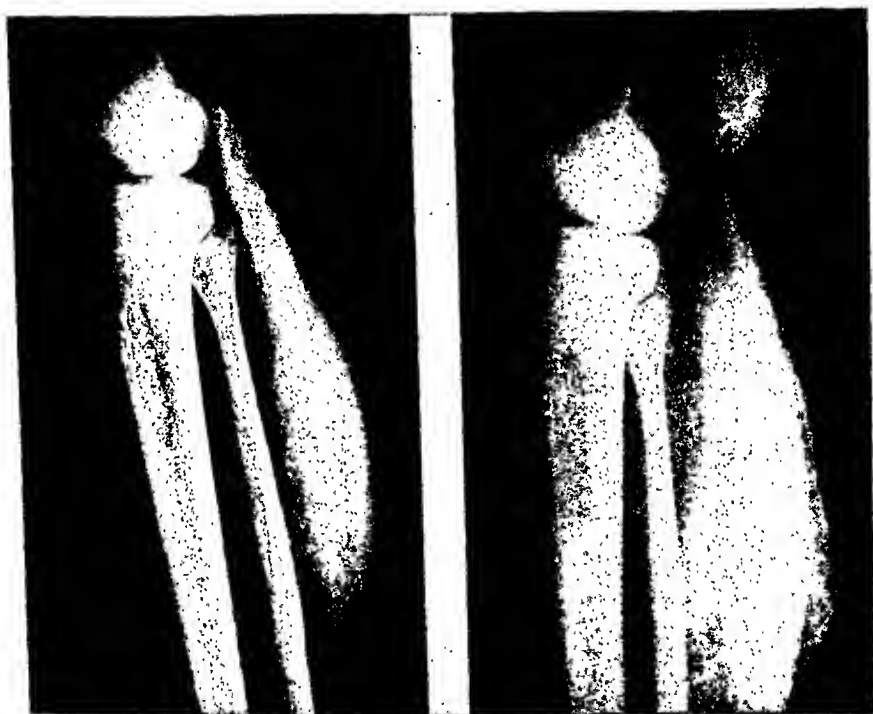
X-ray of upper third of leg. *A*, Normal; *B*, elephantiasis.
